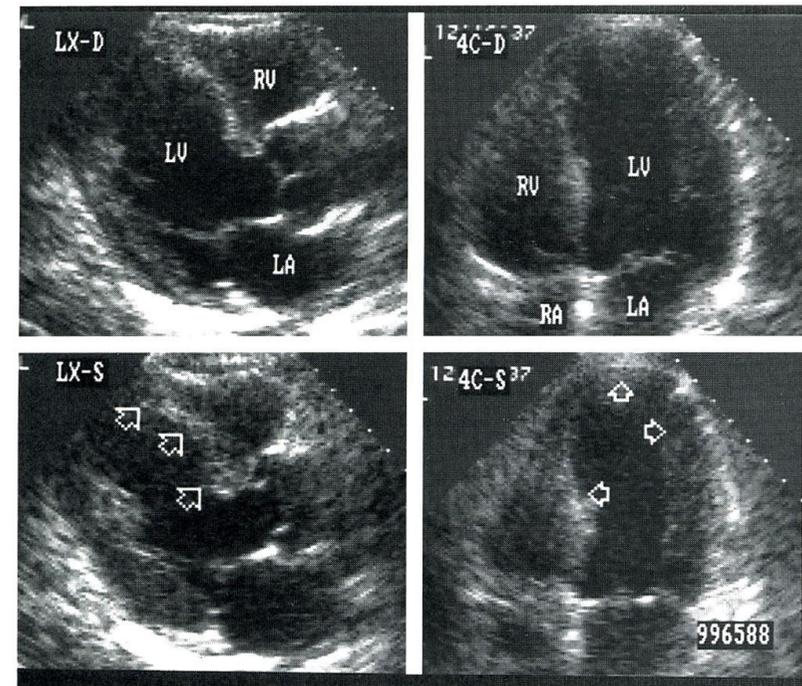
Long-axis (LX) and four-chamber 2-D echocardiogram of a patient with an anterior myocardial infarction secondary to occlusion of the left anterior descending artery. In systole there is akinesis (arrows) of the anterior septum (LX-S) and distal septum, apex, and apical lateral wall (4C-S). LV = left ventricle; RV = right ventricle; LA = left atrium; RA = right atrium.
